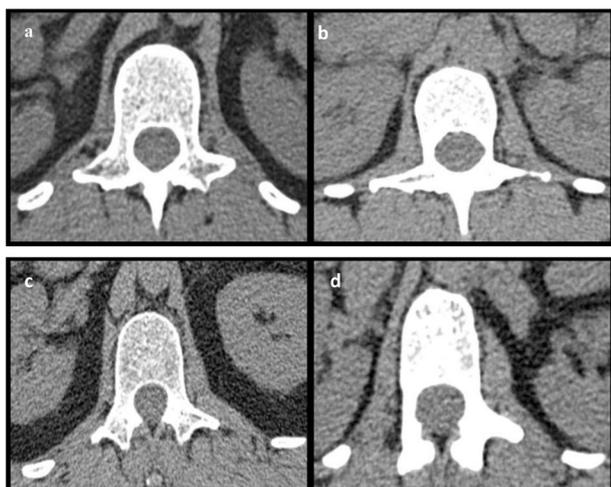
The images show a CT images, axial cut in L1 vertebra. Image a represents the patient with greater entropy. Image b represents the patient with greater uniformity. Image c represents the control with greater entropy. Image d represents the control with greater uniformity
